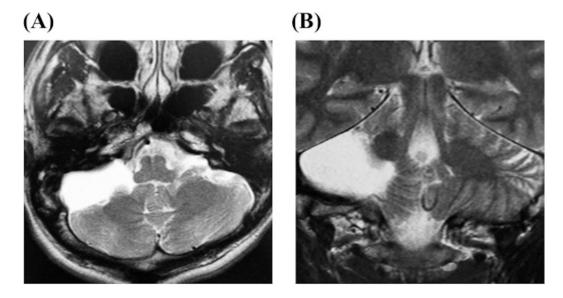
A 35-year-old male suffered from mild headache presented with arachnoid cyst at the cerebellopontine angle on MRI (A; axial section and B; coronal section on T2WI). His symptoms did not include the insufficiencies of vestibular nerve and facial nerve, therefore, no operative indication was considered. And headache disappeared after a little while.
